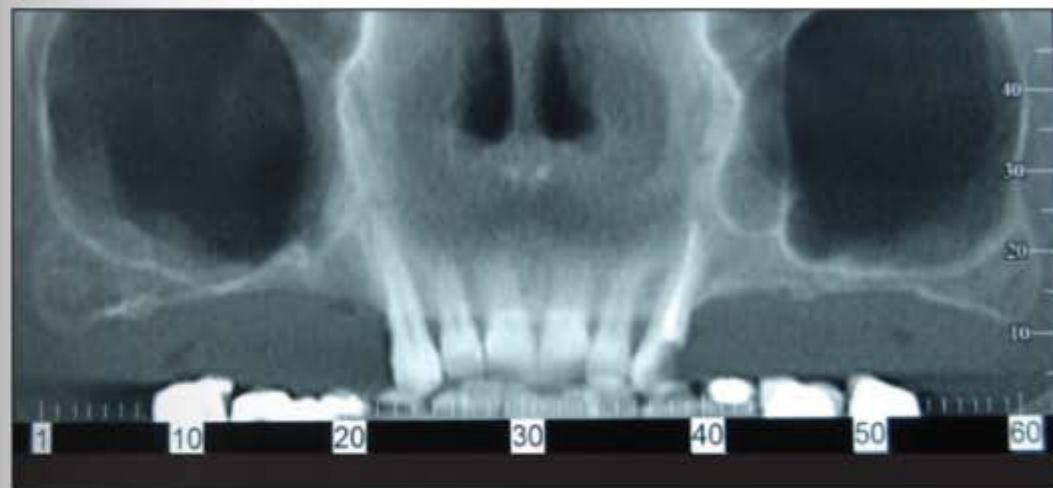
Computed tomography scan of both sinuses in which the bilateral alveolar ridge deficiency is obvious.
